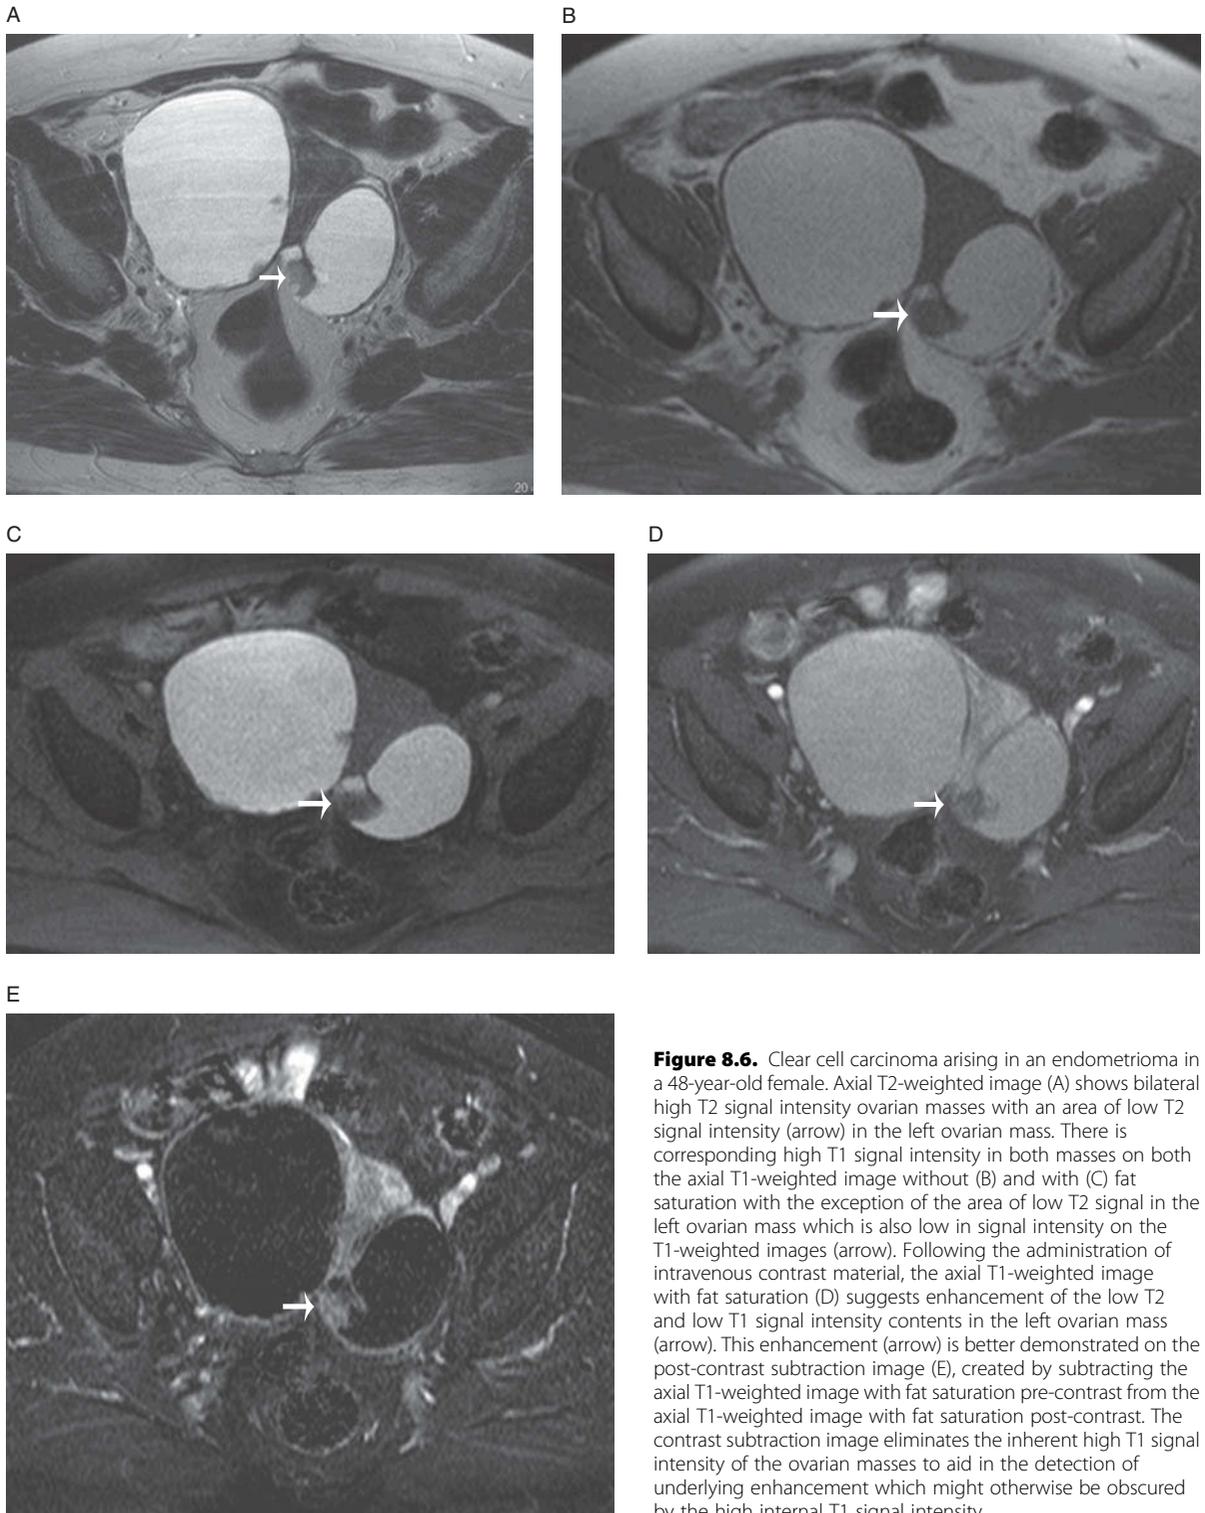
Clear cell carcinoma arising in an endometrioma in a 48-year-old female. Axial T2-weighted image (A) shows bilateral high T2 signal intensity ovarian masses with an area of low T2 signal intensity (arrow) in the left ovarian mass. There is corresponding high T1 signal intensity in both masses on both the axial T1-weighted image without (B) and with (C) fat saturation with the exception of the area of low T2 signal in the left ovarian mass which is also low in signal intensity on the T1-weighted images (arrow). Following the administration of intravenous contrast material, the axial T1-weighted image with fat saturation (D) suggests enhancement of the low T2 and low T1 signal intensity contents in the left ovarian mass (arrow). This enhancement (arrow) is better demonstrated on the post-contrast subtraction image (E), created by subtracting the axial T1-weighted image with fat saturation pre-contrast from the axial T1-weighted image with fat saturation post-contrast. The contrast subtraction image eliminates the inherent high T1 signal intensity of the ovarian masses to aid in the detection of underlying enhancement which might otherwise be obscured by the high internal T1 signal intensity.
